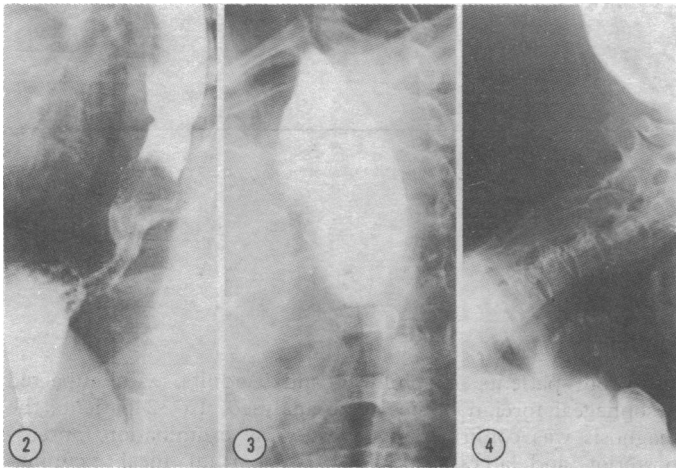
Barium meal film in 45-year-old woman showing foreign body (meat) in lower end of oesophagus. No history of oesophageal obstruction. FIG. 3—Barium meal film in 31-year-old man who ingested caustic soda when 11 years showing complete obstruction of mid-oesophagus by foreign body (meat). Next to obstruction oesophagus is moderately dilated. FIG. 4—X-ray picture of 56-year-old patient with ankylosing spondylitis and history of repeated episodes of food impaction showing severe deformity in upper thoracic spine due to disease.
